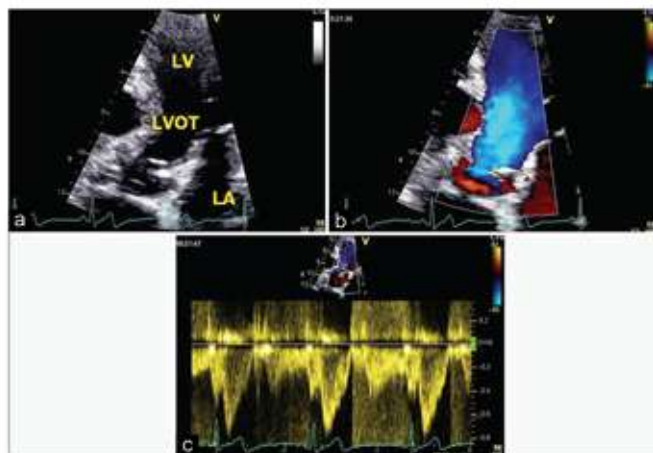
Magnified view of the left ventricular outflow tract; (a) two-dimensional image, (b) with color, (c) left ventricular outflow tract flow on pulsed-wave Doppler. LA- left atrium, LV- left ventricle, LVOT- left ventricular outflow tract
